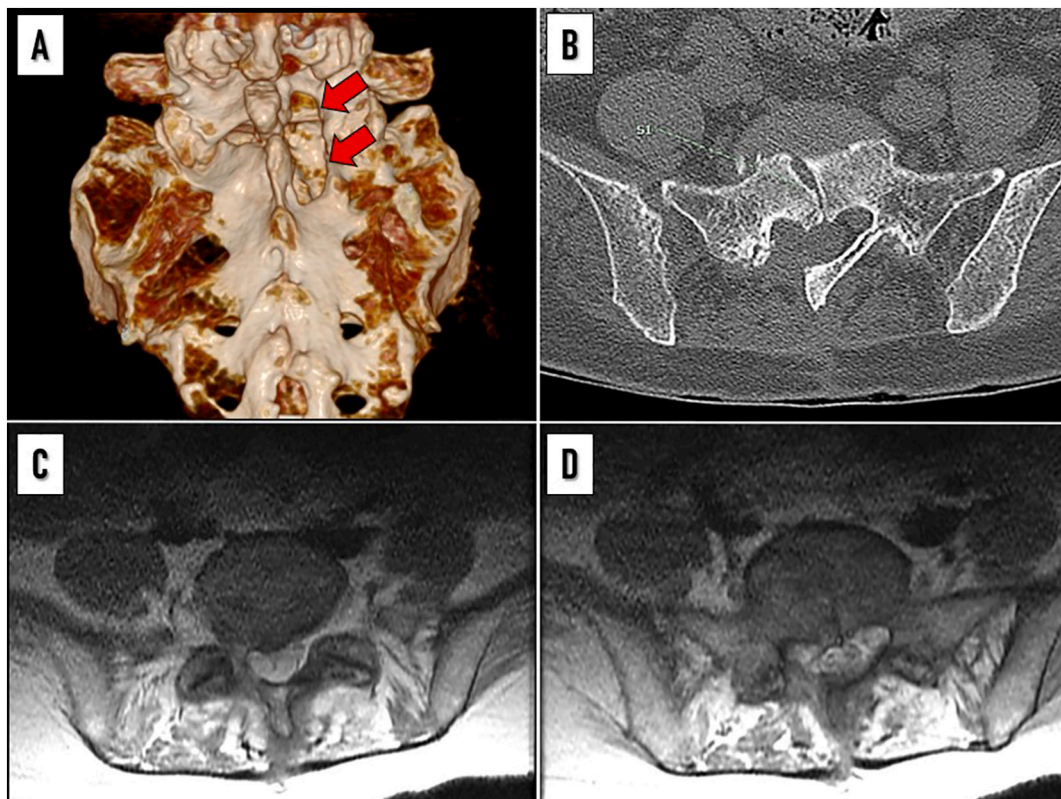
Reconstruction images of sacrum after decompression. Posterior view (A). CT scan of S1 level, Axial view (B). Axial view of MRI, L5 level (C) and L5/S1 level (D).
